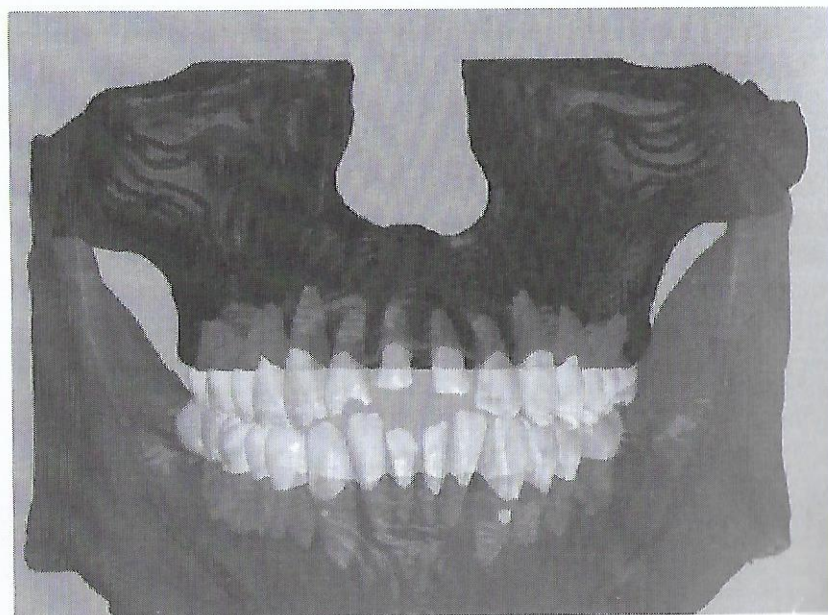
Jaw, individual tooth and inferior alveolar nerve canal (IAC) segmentation by Diagnocat from a raw CBCT data
